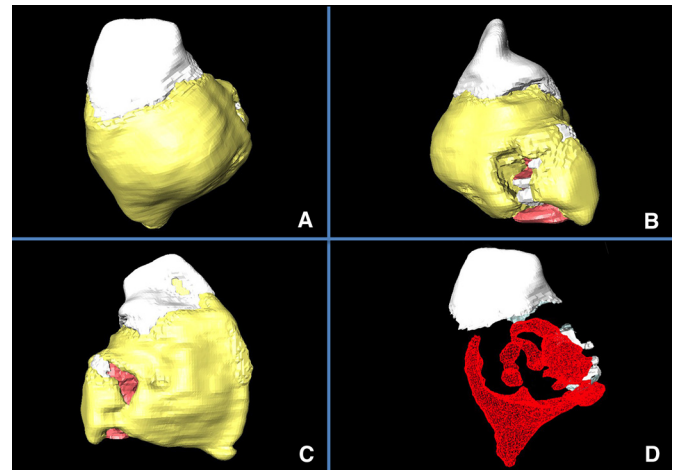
Reconstructed 3D CBCT images of the final volume of the dilated odontoma in 16-bit. Each type of tissue was characterized by a color. The enamel-like mineralized tissue was colored in white, the cement-like structure was in yellow whereas the non-mineralized pulp-tissue was in red. (A) Labial view. (B) Mesial view. (C) Lingual view. (D) Internal view showing the complex anatomy of the pulpal canal and enamel invagination (in white).
